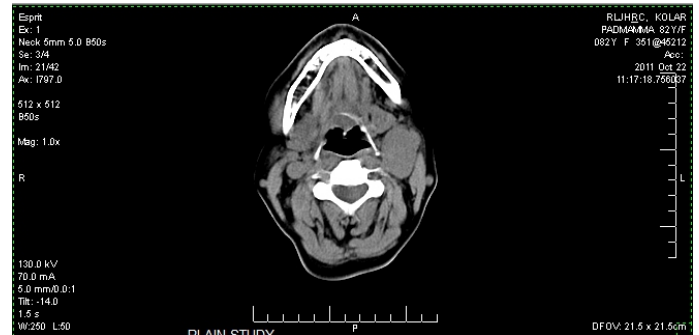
Cervical contrast enhanced CT showing left carotid body tumour
